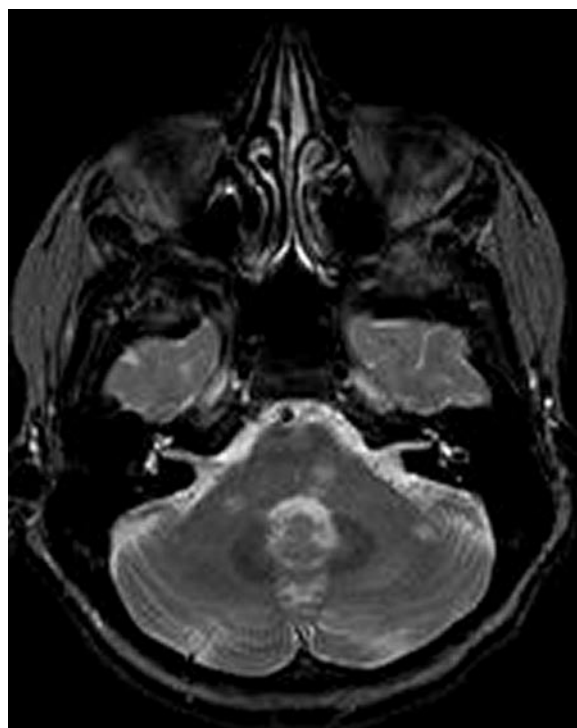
Infratentorial MS plaques. Axial T2-weighted image. Hyperintense lesions in the pons, pedunculus cerebelli medius, and the white matter of the left cerebellar hemisphere. These are typical localizations for inflammatory lesions. One criterion for dissemination in space is fulfilled if at least one infratentorial lesion is present
